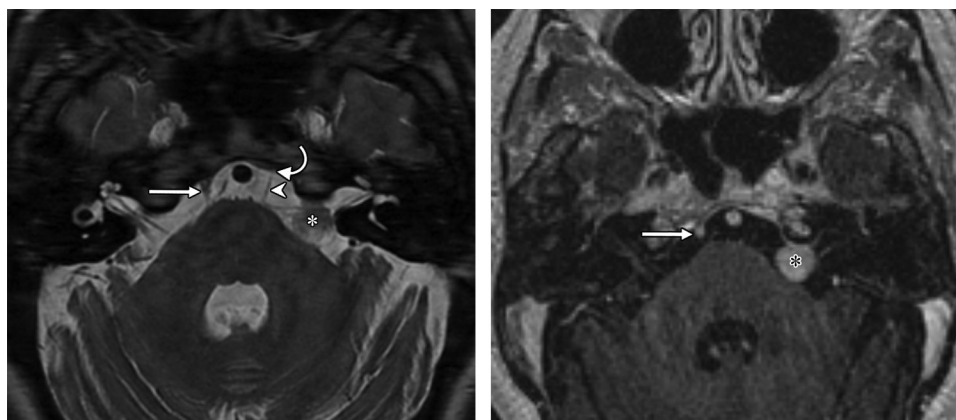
Clinically diagnosed CN VI schwannoma and lower CN schwannoma in a 67-year-old woman. (a) Axial T2-weighted MR image shows asymmetric enlargement of the distal cisternal segment of right CN VI (straight arrow) as it enters the Dorello canal. The contralateral CN VI cisternal segment (arrowhead) is coursing from the ventral pons through the prepontine cistern into the Dorello canal (curved arrow). A larger left lower CN schwannoma (*) is present. (b) Axial contrast-enhanced T1-weighted MR image shows enhancement of both the small right CN VI schwannoma (arrow) and larger left lower CN schwannoma (*).
